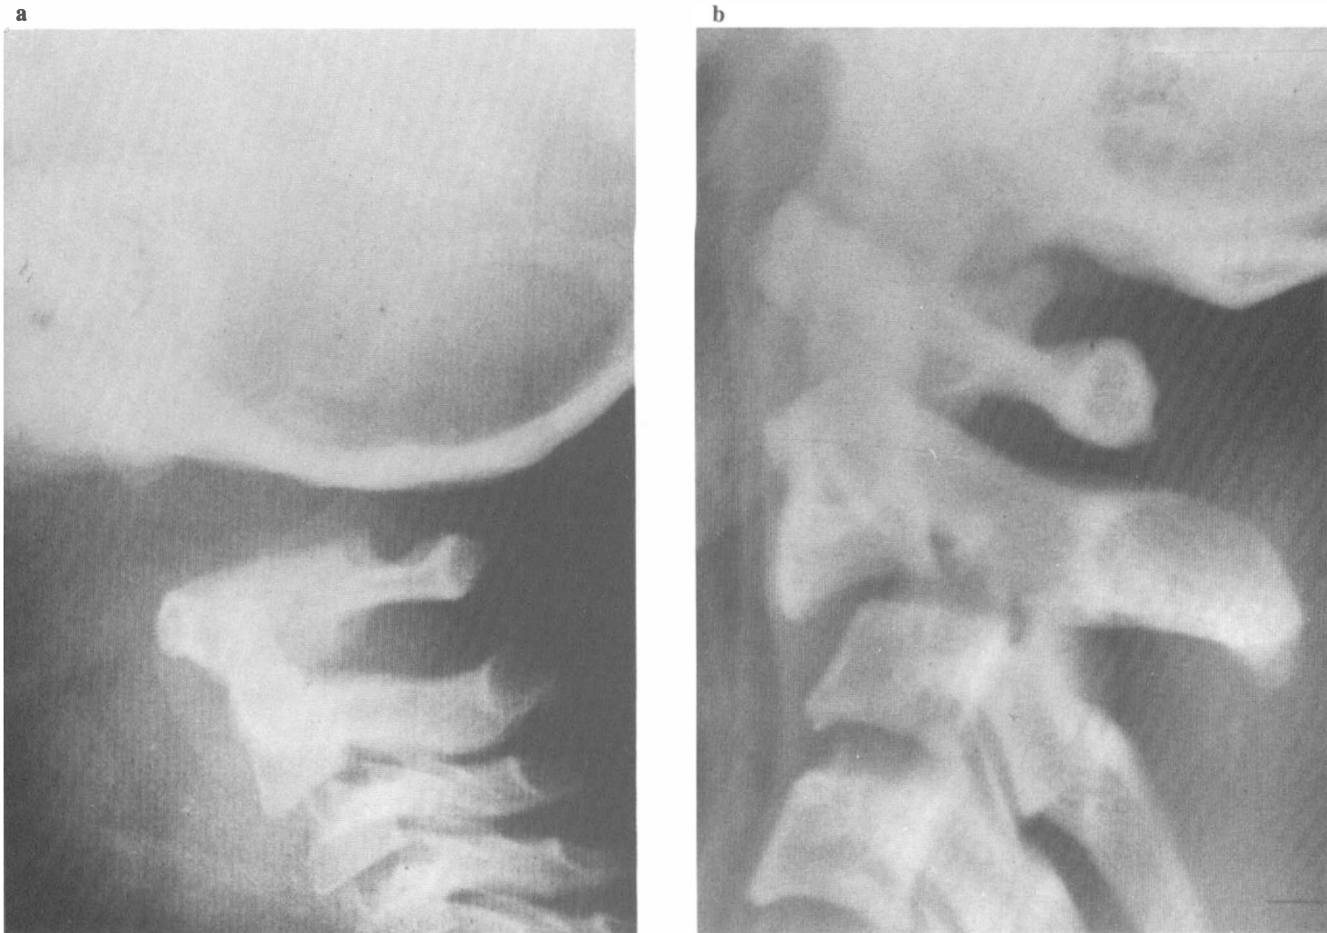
Anterior interbody fusion of C2-3 for type II hangman's fracture. (a) This 31-year-old man had Brown-Séquard syndrome and C2 neuralgia. Preoperative lateral roentgenogram showed a type II hangman's fracture. (b) Postoperative lateral roentgenogram showed solid bony union of the hangman's fracture
